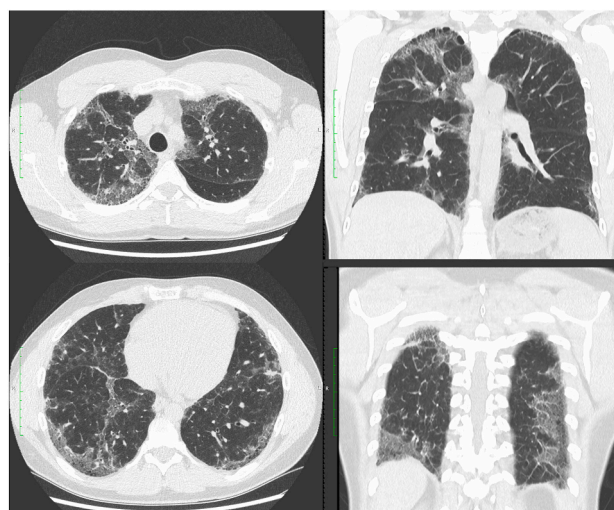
Axial and coronal high resolution computed tomography images demonstrating bilateral pulmonary infiltrates without clear zonal gradient. There is involvement of both the peripheries at the bases, and the peribronchovascular space in the upper zones. Features of fine lace-like reticulations, upper lobe honeycombing without lower lobe involvement, and an absence of airway centred inflammation or ground glass infiltrates. This pattern is not consistent with either UIP or NSIP, and was determined to be radiologically unclassifiable.
